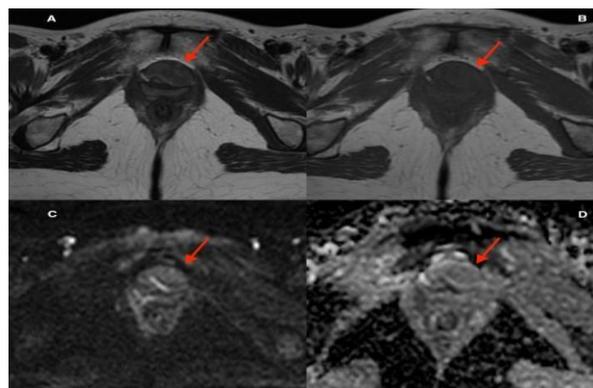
T2-weighted axial image (A) shows a hypointense round well-defined mass on the left anterior side of the urethra (red arrow), referring to a urethral leiomyoma. The mass appears hypointense on the T1-weighted images (B), without significant restriction of the diffusion coefficient, showing low signal on the DWI axial images (C) (b value= 1000) and high signal on the ADC map (D). Note that both on the T2-weighted and T1-weighted images the signal intensity is very similar to that of the muscles. After paramagnetic contrast medium administration, the mass showed enhancement higher on the late phase (Figure 3). The suspicion of paraurethral leiomyoma was raised.
